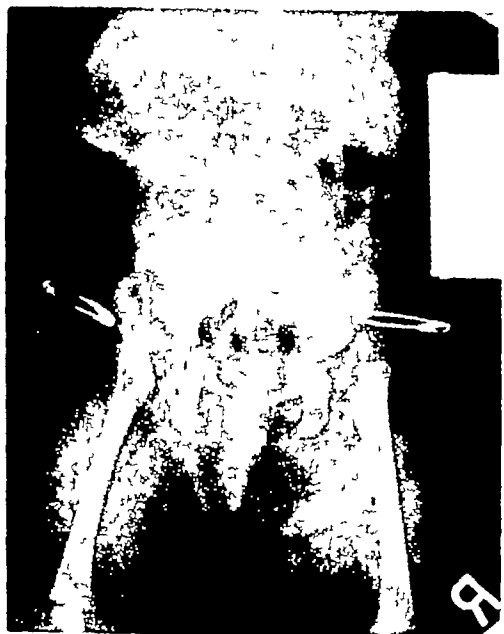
X-ray of newborn infant Congenital dislocation of both hips, embryonal or primary type. Note absence of capital femoral epiphyseal centers of ossification and external rotation of both legs.
